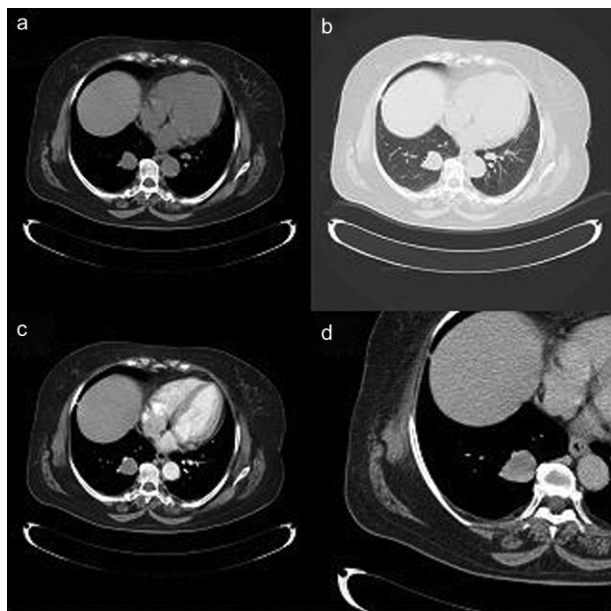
Chest computed tomography (CT) shows a solitary pulmonary nodule (SPN) in the inferior lobe of the right lung. (a) plain scanning; (b) lung window; (c) early contrast-enhanced CT scan; (d) delayed contrast-enhanced CT scan.
